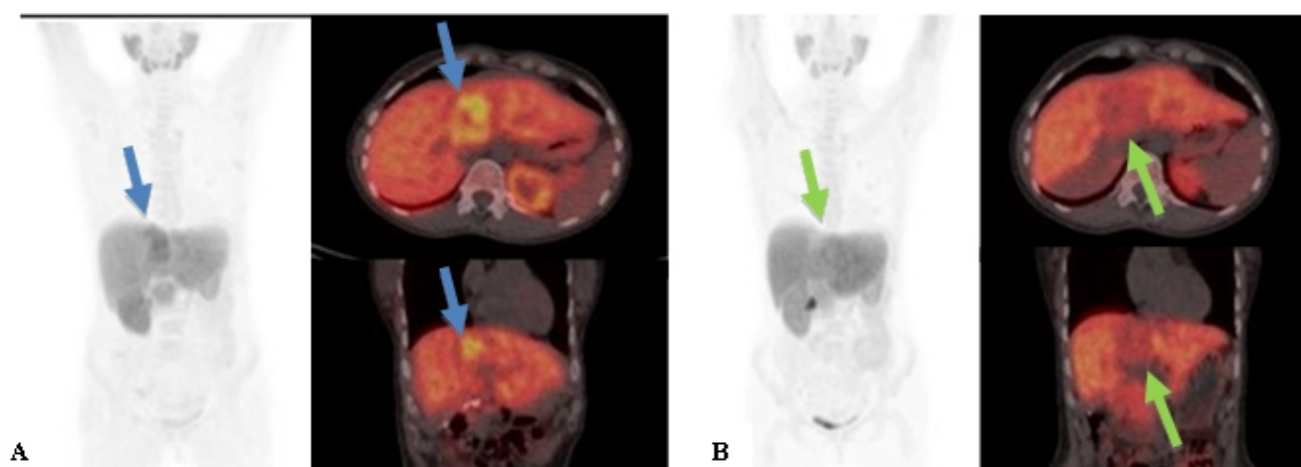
A 35 year old woman, evaluated with ^{18}F -FCH PET/CT for Focal Nodular Hyperplasia (FNH) of VIII-IV-I hepatic segments. A: Pre-treatment ^{18}F -FCH PET/CT: expected increased uptake in the Focal Nodular Hyperplasia (VIII-VI-I segments). Treatment with yttrium-90 (^{90}Y). B: Post-treatment ^{18}F -FCH PET/CT: expected decreased uptake area in I-IV hepatic segments (treatment result).
